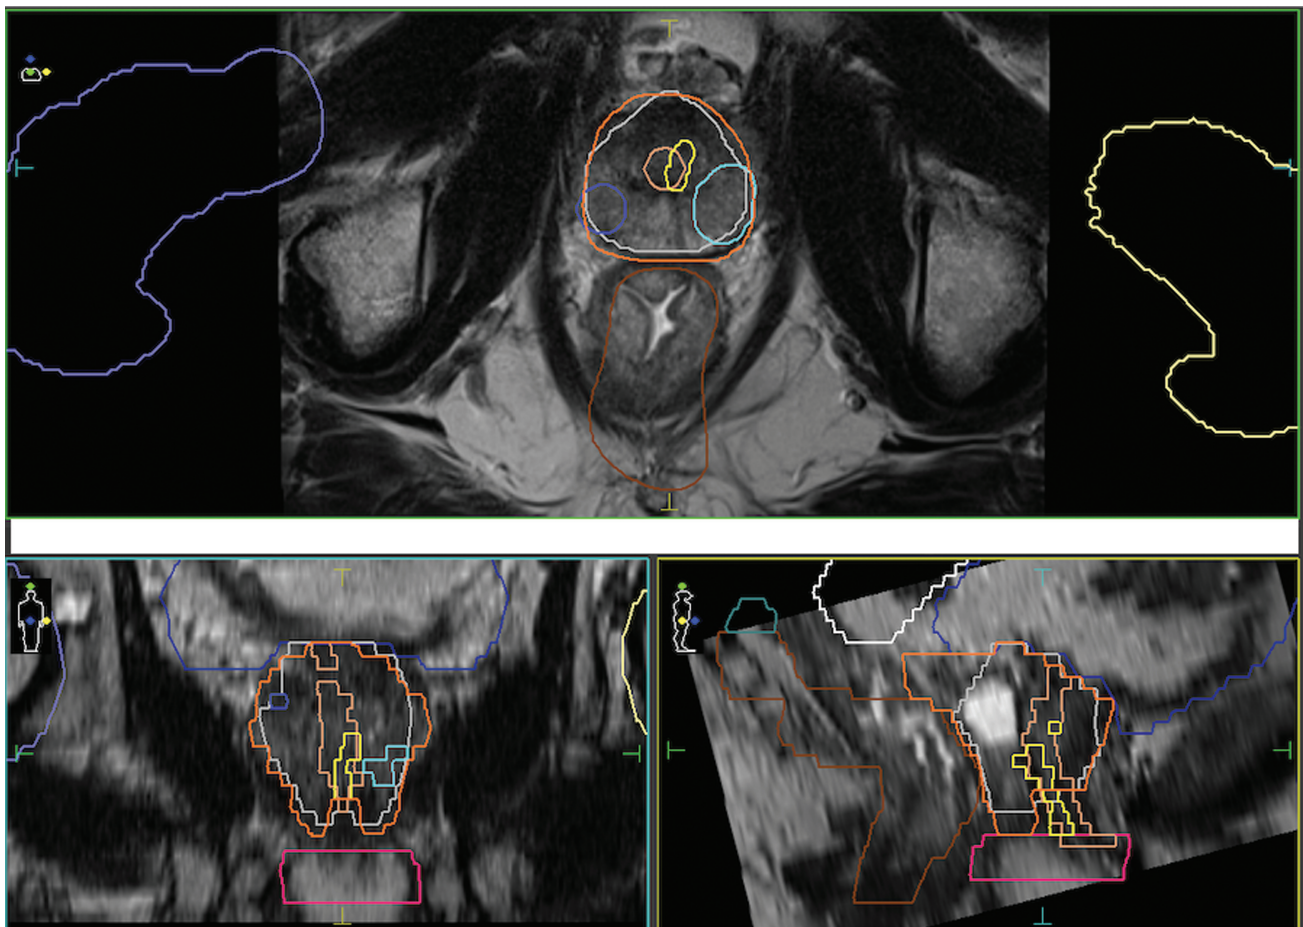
Magnetic resonance imaging scan fusion with computed tomography scan.
